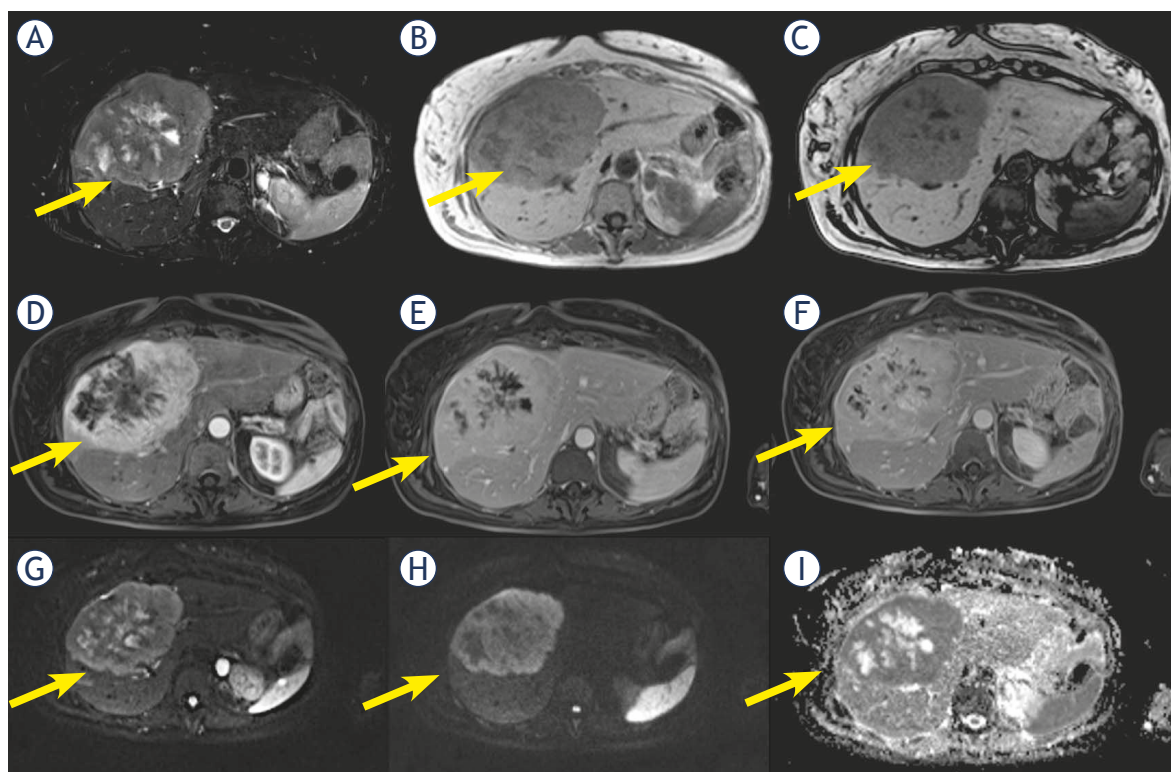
Woman 58 y with combined hepatocellular-cholangiocarcinoma (cHCC-CCA) on IV-V-VIII hepatic segment. MRI study. Pre surgical radiological diagnosis was cholangiocarcinoma (CCA). The lesion shows inhomogeneous hyperintense signal (arrow) in T2-W sequence (A) with central more hyperintense area. In T1-W in-out phase sequence (B and C) the lesion is inhomogeneous hypointense (arrow). During contrast study (D: arterial phase, E: portal phase; F: late phase) the lesion shows progressive contrast enhancement (arrow). In diffusion weighted imaging (DWI) (G, H and I) it shows restricted diffusion (arrow).
